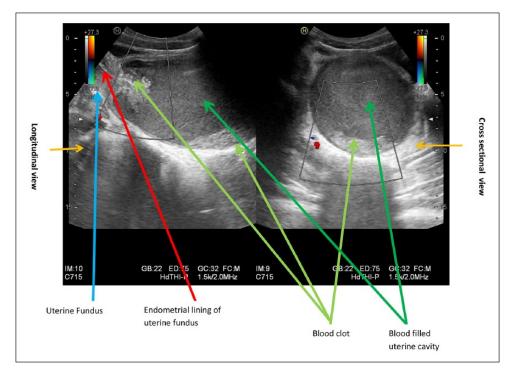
Ultrasonographic image of imperforate hymen.
